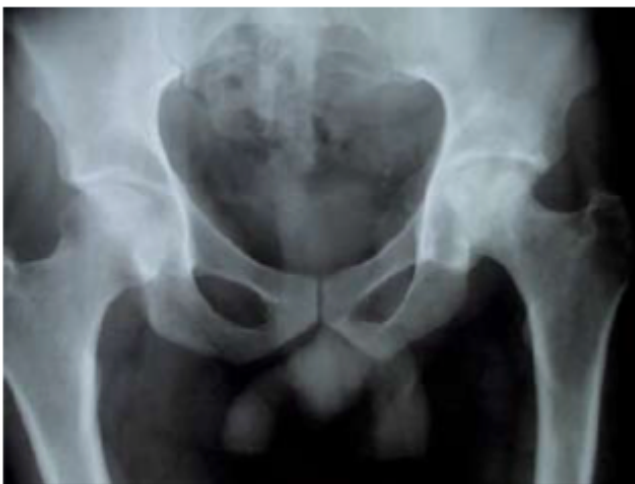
Hip X-ray 1 year after treatment shows the femoral head necrosis due to the septic arthritis.
